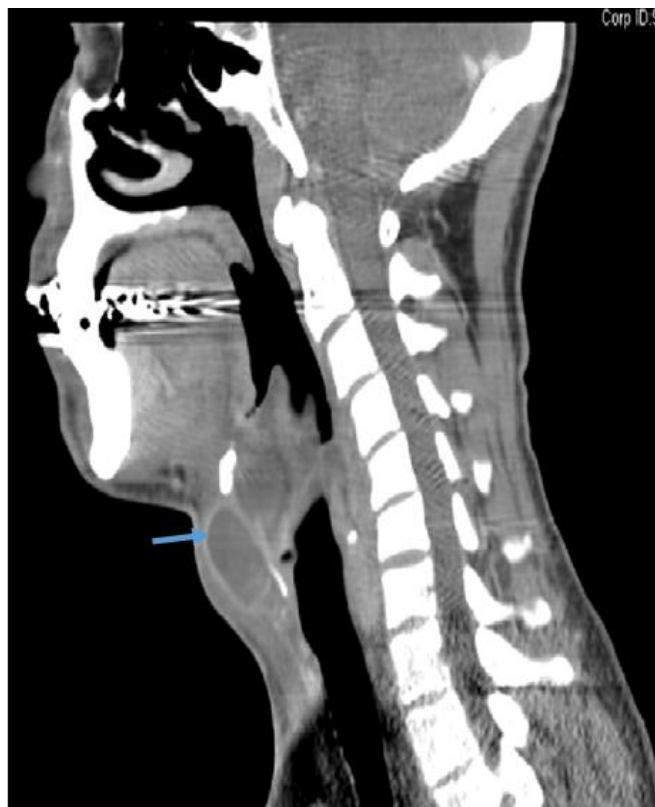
Repeat CT neck soft tissue showed minimal interval enlargement of abscess [Arrow]
